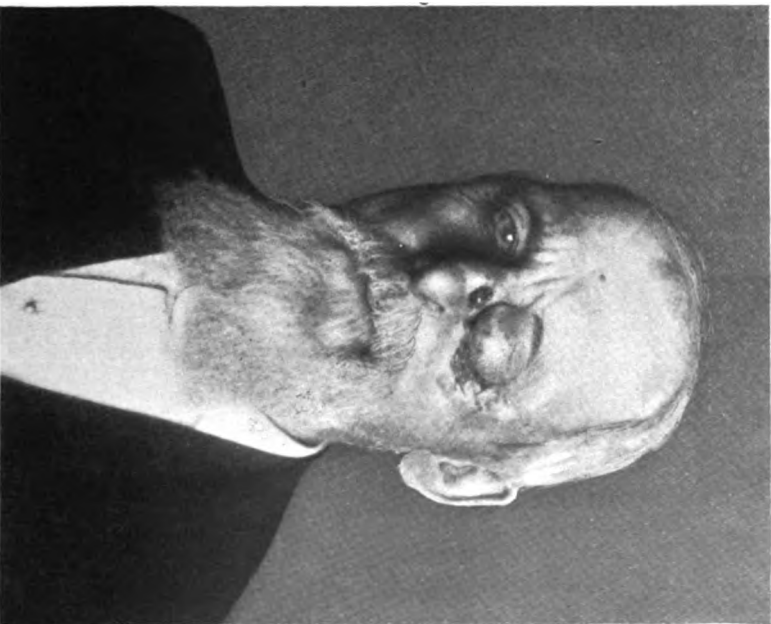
Result of x-ray treatment of patient shown in Fig. 30.
